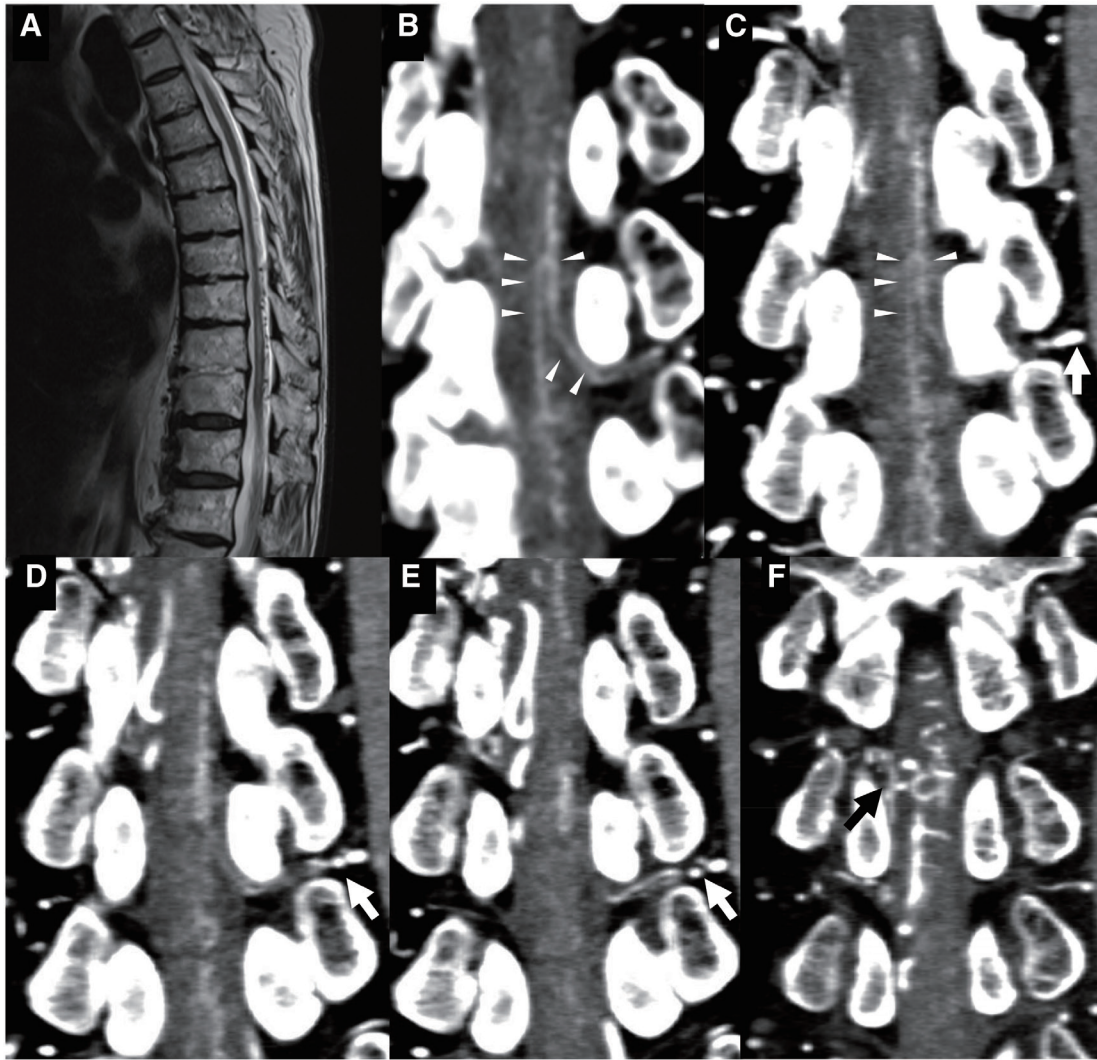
(A) A sagittal section of MRI displaying the high T2 signal at the level from Th7 to Th12, along with flow voids. (B and C) The hairpin curve of the AKA is depicted on the oblique coronal and coronal MPR images of CTA (white arrowhead). (D and E) The continuity from the left ninth intercostal artery to the anterior surface of the spinal cord is distinctly observed on the coronal image of CTA (white arrow). (F) In the coronal view of the CTA, a shunt supplied by the right seventh intercostal artery as the feeder is observed; however, the exact shunt point cannot be definitively identified (black arrow). AKA, artery of Adamkiewicz; MPR, multiplanar reconstruction
